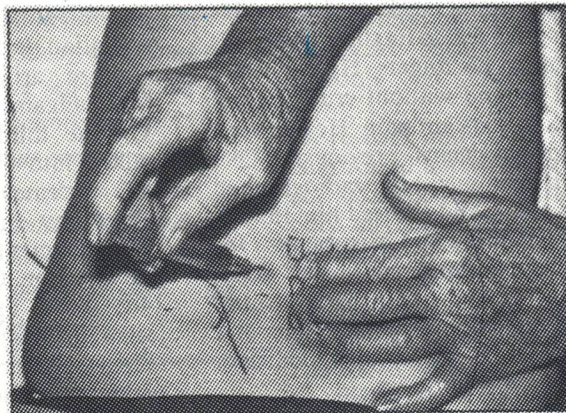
Left L-4 facets (study radiographs)—this joint is not deep.
